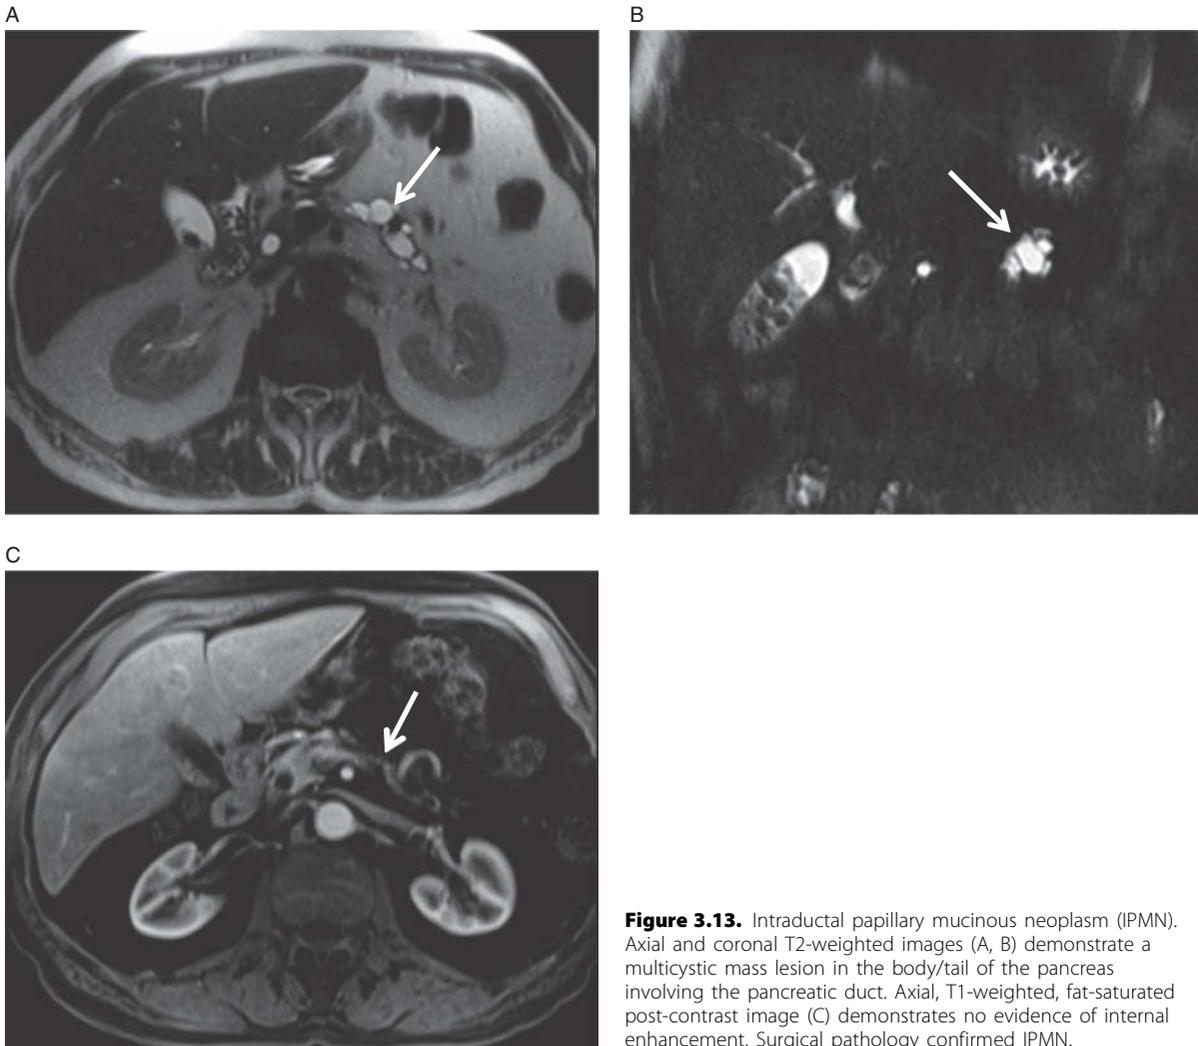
Intraductal papillary mucinous neoplasm (IPMN). Axial and coronal T2-weighted images (A, B) demonstrate a multicystic mass lesion in the body/tail of the pancreas involving the pancreatic duct. Axial, T1-weighted, fat-saturated post-contrast image (C) demonstrates no evidence of internal enhancement. Surgical pathology confirmed IPMN.
